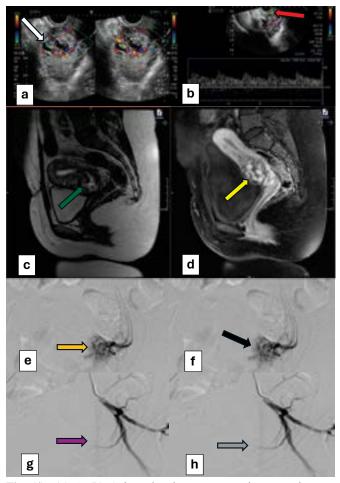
(a) & (b) Colour doppler sonogram shows cystic mass with mosaic pattern of peripheral vascularity at previous caesarean section site (White and Red arrows). Doppler examination shows low resistance high velocity flow. (c) & (d) T2 sagittal and T1 post contrast sagittal images show a heterogeneous bulging mass with serpentine signal voids involving the lower uterine cavity and anterior myometrium with patchy post contrast enhancement at site of LSCS scar, suggestive of uterine AVM. (e) & (f) Right and left uterine artery pre-embolization runs show abnormal blush of vessels (Orange and black arrows). (g) & (h) Right and left uterine artery post-embolization runs show complete resolution of abnormal blush. (Purple and grey arrows).
